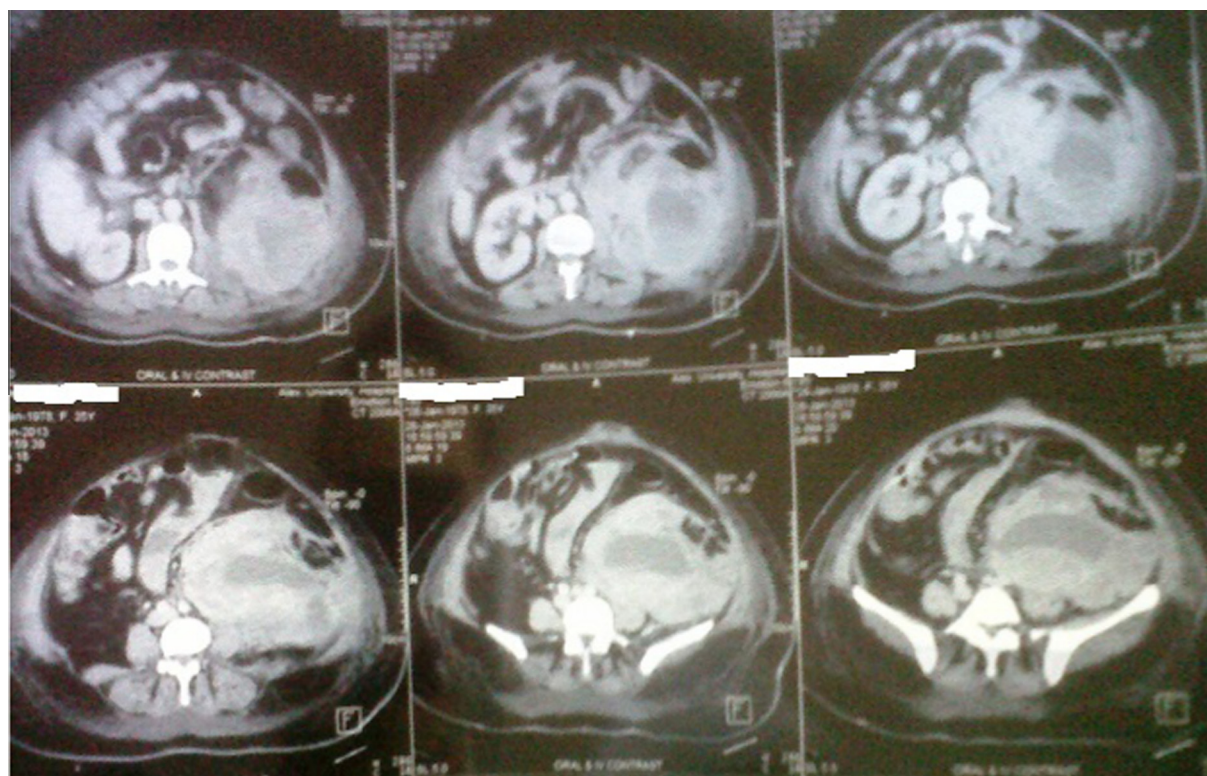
Abdominal CT revealed retroperitoneal haematoma.
